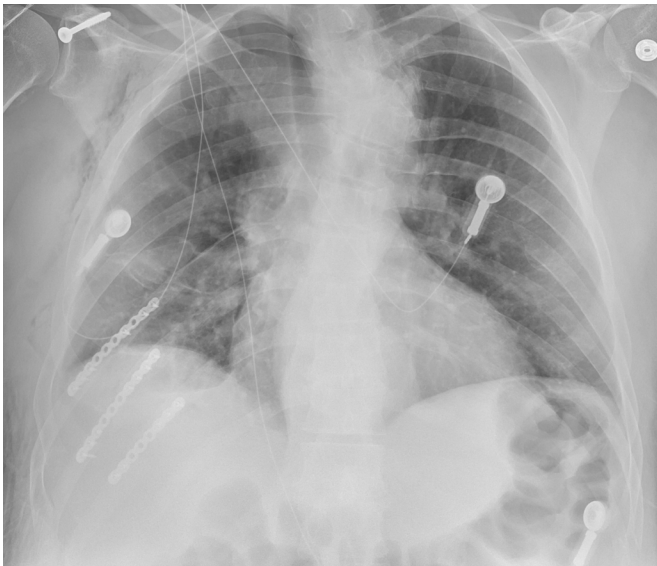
Final chest X-ray prior to discharge.
